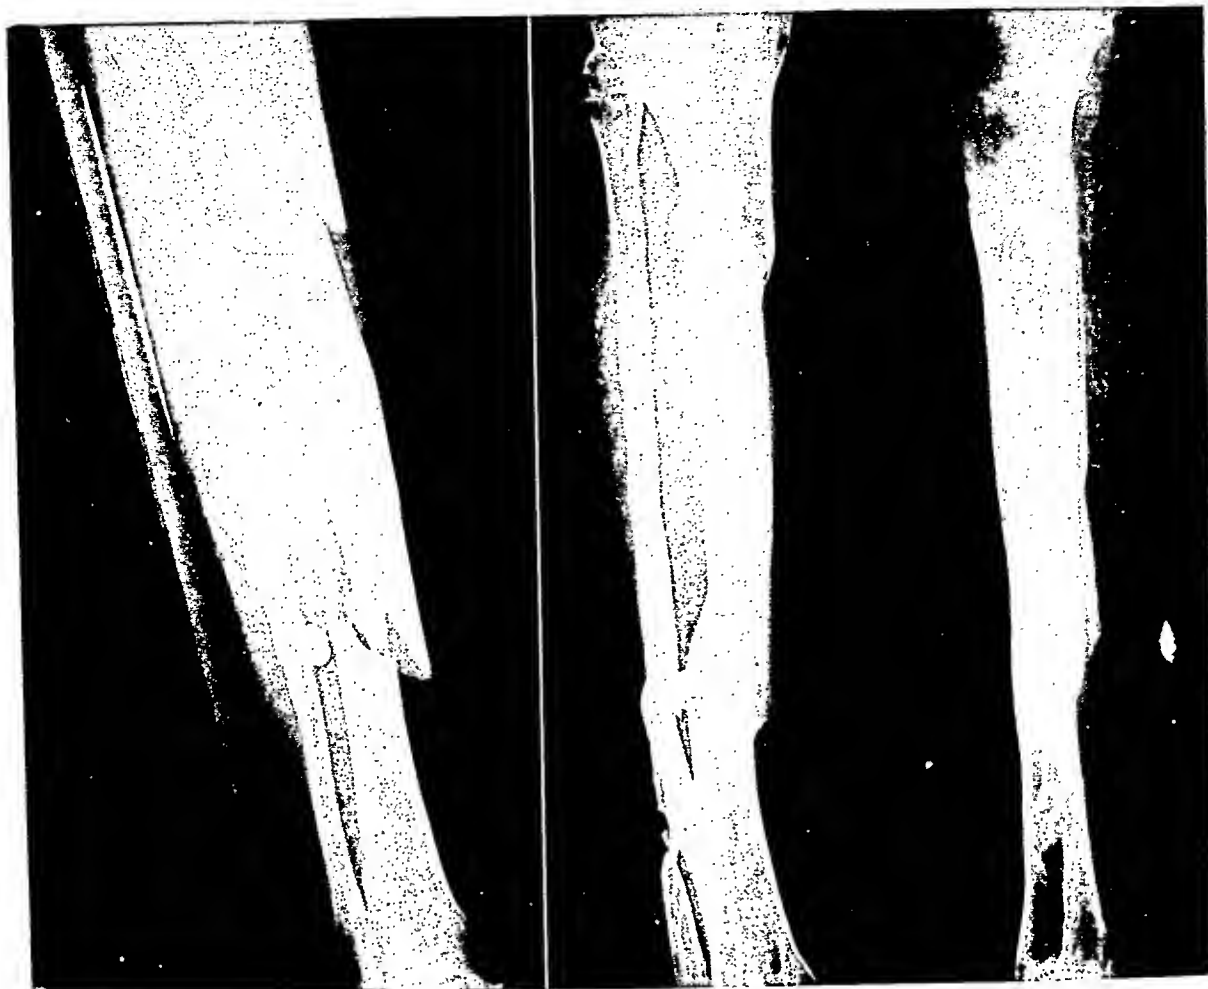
A, double non-union of the tibia four months after the accident. B, fistula transferred in two stages. First stage, fusion of upper tibiofibular joint (note bone peg through head of fibula into the tibia); second stage, six weeks later osteotomy between middle and distal third of fibula and fusion of proximal fragment of fibula to tibia. This roentgenogram was taken one year after the first operation.
